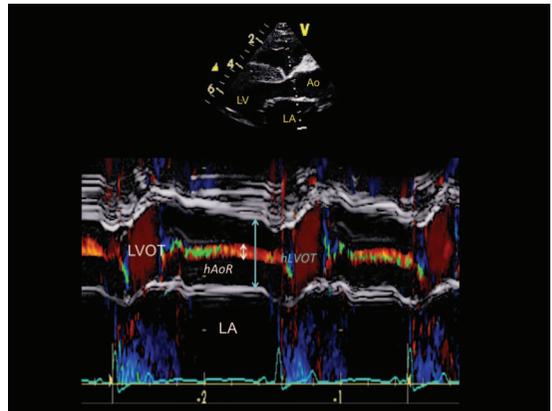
Color M-mode echocardiogram obtained from the right parasternal five-chamber view in an “apparently healthy” cheetah (*Acinonyx jubatus*). An aortic regurgitation (AoR) is present during the whole diastolic phase, and its color-coded height (hAoR, short double arrow) can be measured to calculate the jet height ratio (i.e., hAoR divided by the left ventricular outflow tract height [hLVOT, long double arrow]). The jet height ratio value is 24%, thus confirming a moderate AoR. Ao indicates aorta; LA, left atrium; LV, left ventricle.
